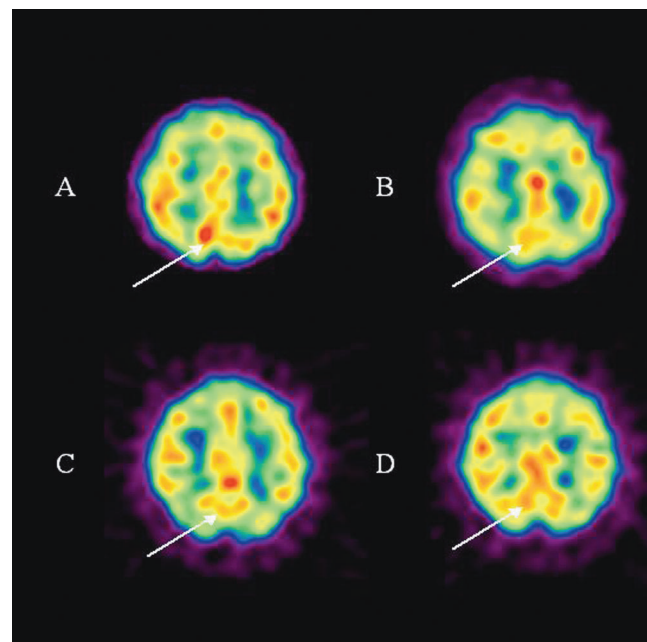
Single-photon emission computed tomography of M technique and precuneus. This figure shows transaxial slices of the brain to show the precuneus. The figure compares the pre and post 1st M technique with pre and post 10th M technique. A. Pre 1st M. B. Post 1st M. C. Pre 10th M. D. Post 10th M. Cerebral blood flow is shown as red > yellow > green > blue. There is a reduction in precuneus activity of approximately 15% from baseline to post M technique (indicated by the arrows).
